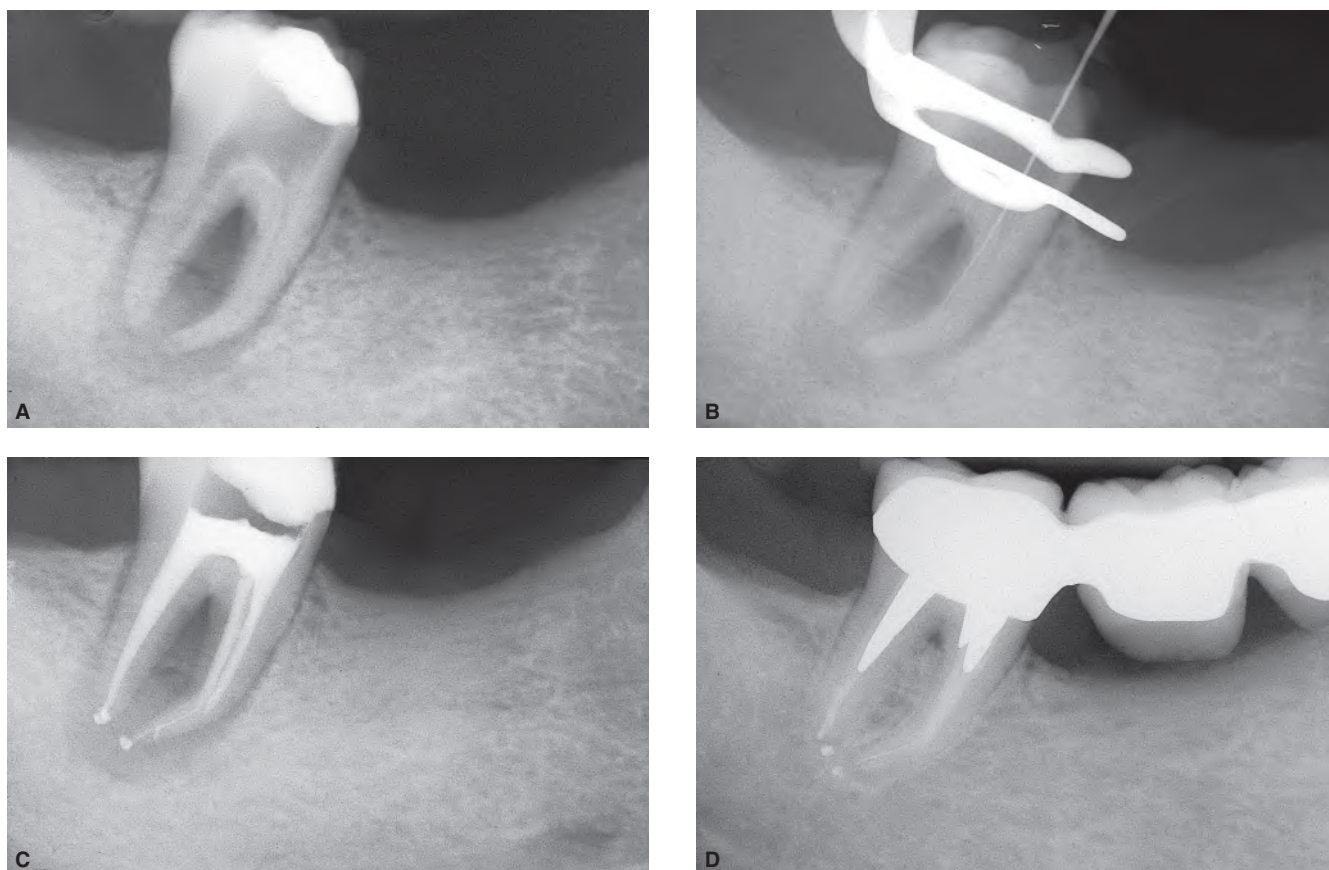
A. Preoperative radiograph of a mandibular right second molar. The patient was referred for treatment after the distal canal had been prepared and the mesial canals were only partially negotiable. B. A ledge was present at the beginning of the curvature of the mesial canals. C. Postoperative radiograph. The distal canal was obturated with warm gutta-percha, and the mesial canals with thermoplastic gutta-percha. Note the filling of the non-instrumented portion of the mesial canals. D. Three-year recall radiograph showing successful results.
